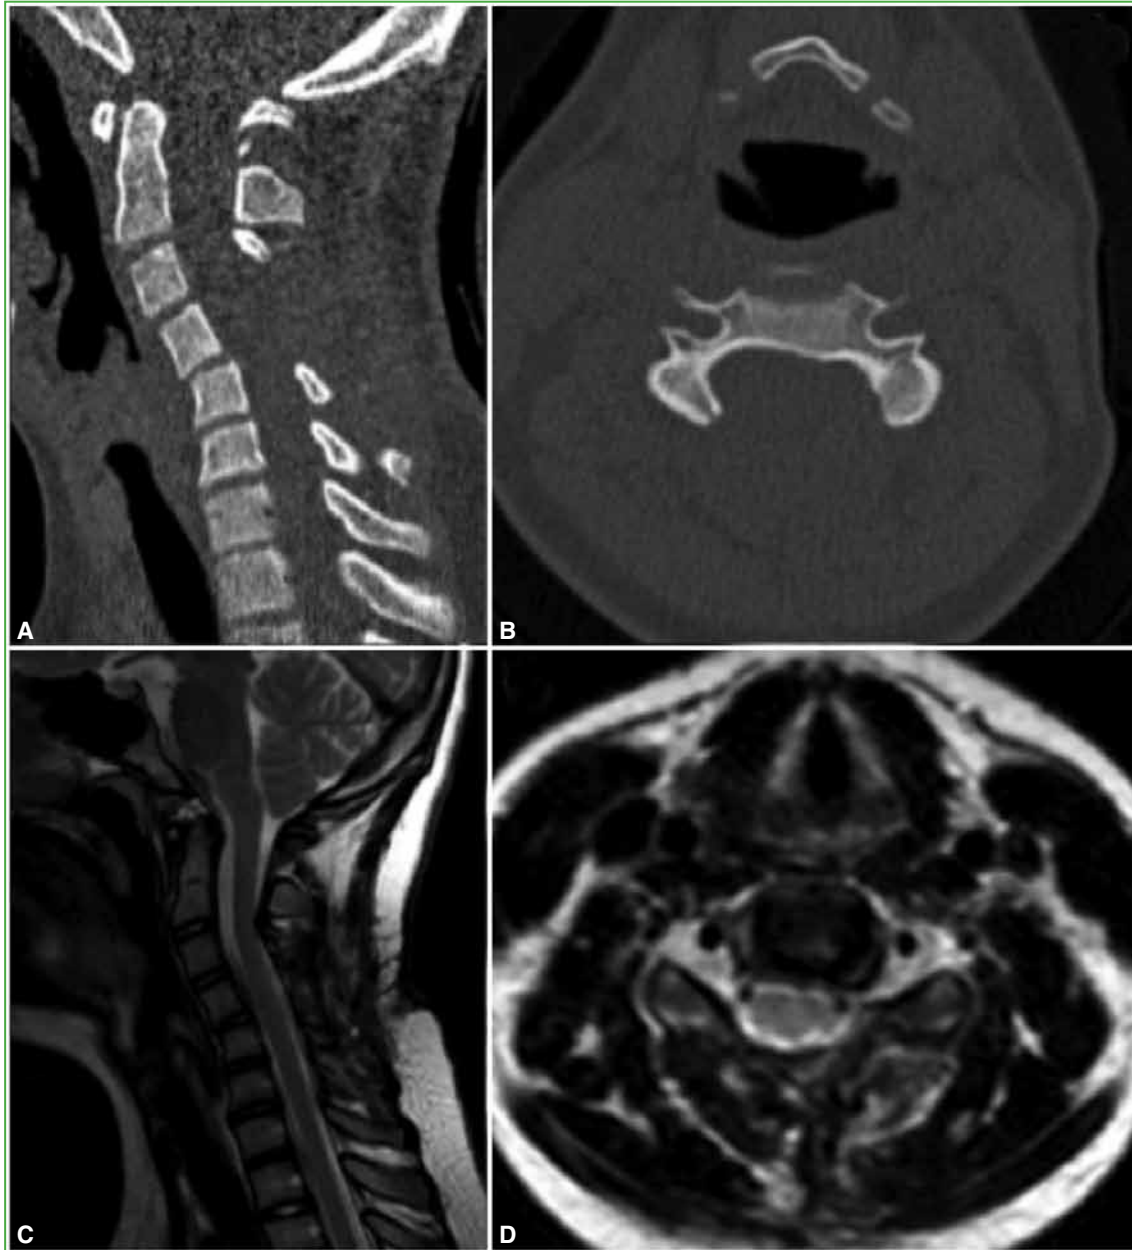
Computed tomography of the cervical spine, sagittal (A) and axial (B) slices, and magnetic resonance of the cervical spine, sagittal, T2 (C) and axial T2 (D) slices. Postoperative control at 24 months.
